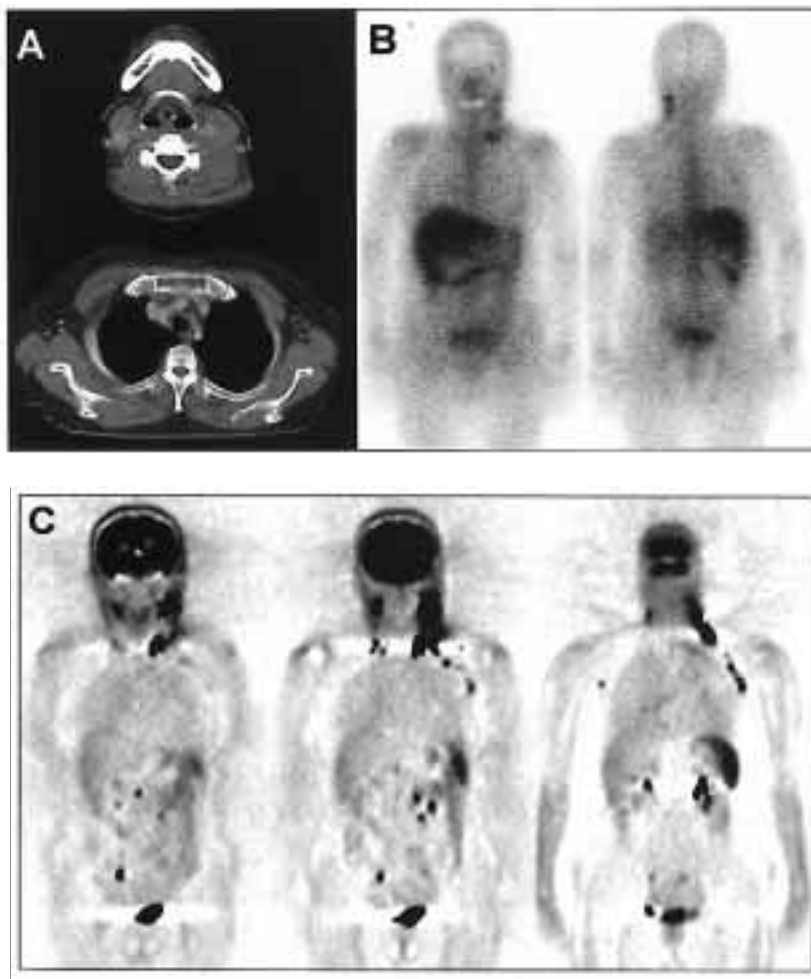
A 70-year-old female patient with extensive, intermediate-grade NHL. A: CT scans demonstrated lymphadenopathy in the left cervical region while only small lymph nodes were shown in the right cervical and left axillary region. B: ^{67}Ga -scintigraphy showed a high uptake in the left cervical and left paraclavicular regions. C: FDG-PET demonstrated an abnormally high uptake in the bilateral cervical, paraclavicular, axillary, mesenteric and right para-iliac nodal regions and the spleen.
